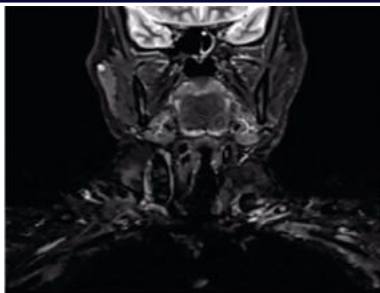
Postoperative coronal MRI of the neck showing no residual or recurrent lesion.
